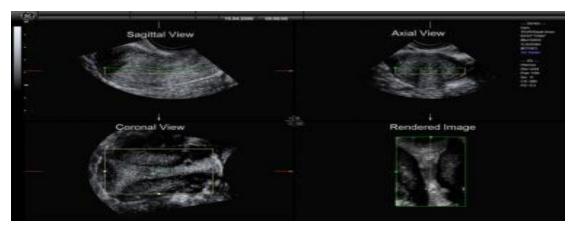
The orthogonal views (sagittal, axial and coronal), as well as the rendered 3D image of the endometrium, taken by vaginal 3-D ultrasound transducer (36).
